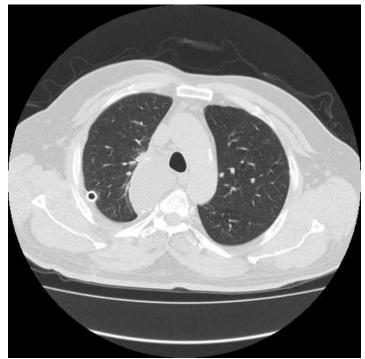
Right paramediastinal lymphatic collection demonstrated on CT image.
